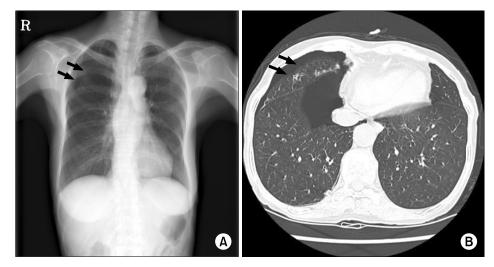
Chest PA view (A) & chest CT (B) shows right-side pneumothorax.
